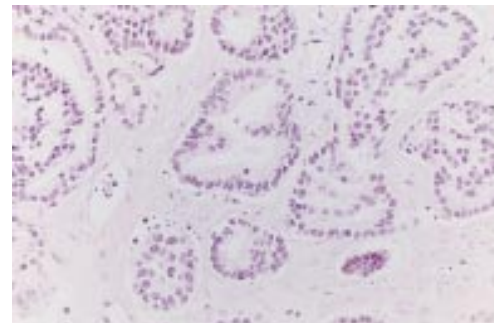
Adenocarcinoma in the centre of a high intensity focused ultrasound lesion without morphological signs of necrosis. Nuclear structures are well preserved and cell borders are locally identified.
